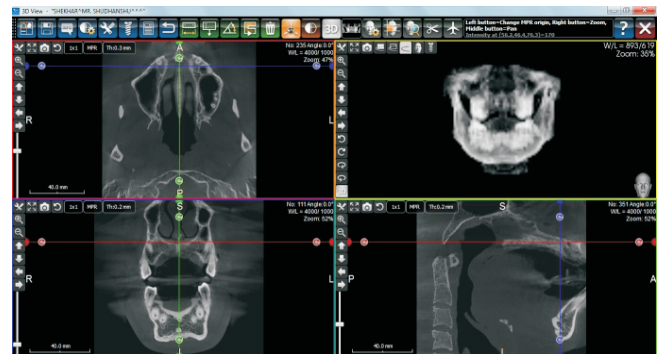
CBCT image acquisition in a software for evaluation of CVMI.
